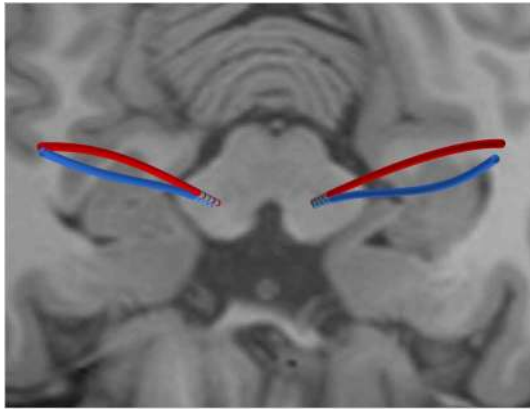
Electrode reconstruction from co-registered CT data one day after surgery (red) and one year later (blue). Co-registered T1 MRI displayed in background. Note the non-linear bending of the trajectories due to brain shift respectively inverse brain shift.
